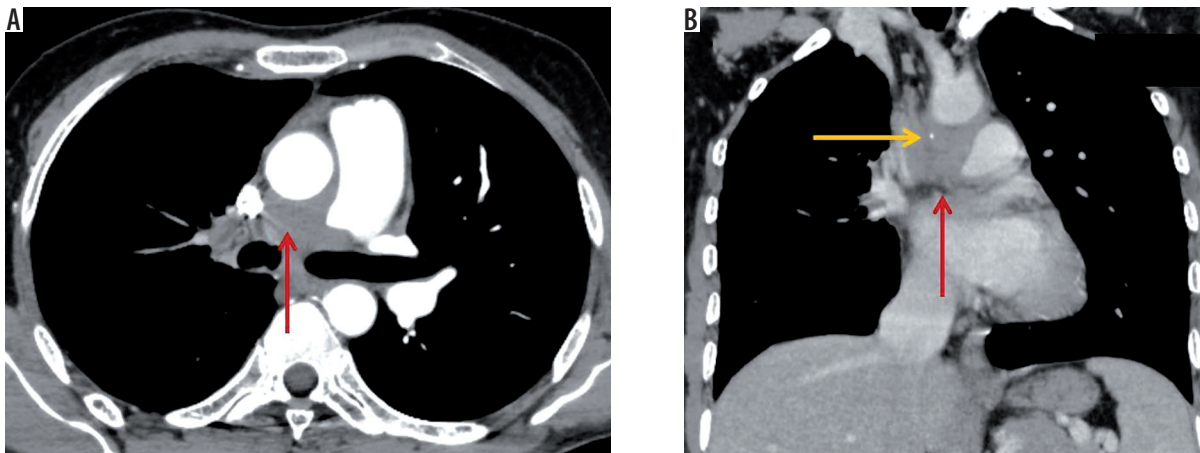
A 55-year-old male patient previously diagnosed with tuberculosis involving mediastinal nodes, presented with progressive dyspnoea. A) Axial and (B) coronal post contrast computed tomography image mediastinal window in a showing an ill-defined soft tissue density mildly homogenously enhancing mediastinal lesion along the right pulmonary artery completely encasing the artery and causing luminal obliteration (red arrow). It shows a focus of calcification (yellow arrow)
